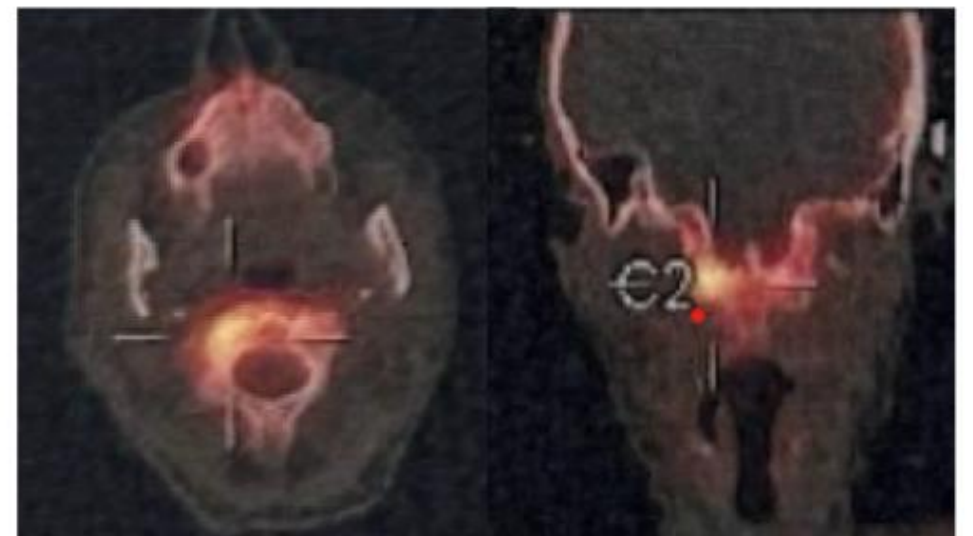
Axial and coronal fused single photon emission CT demonstrate increased radiotracer uptake in within right C1 to C2 facet joint compatible with degenerative facet arthropathy.
